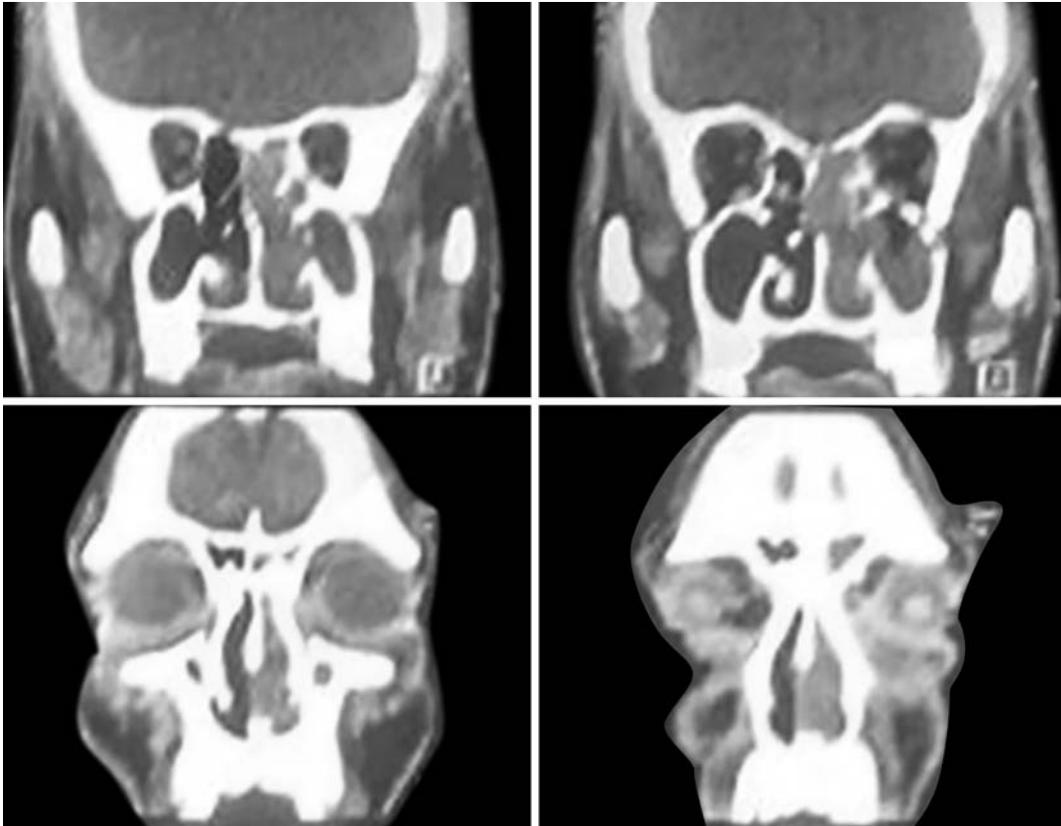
Contrast-enhanced computed tomography paranasal sinus and orbit showed heterogenous enhancing soft-tissue mass filling the left nasal cavity eroding into septum, left maxillary, ethmoid and sphenoid sinus and extending into nasopharynx
